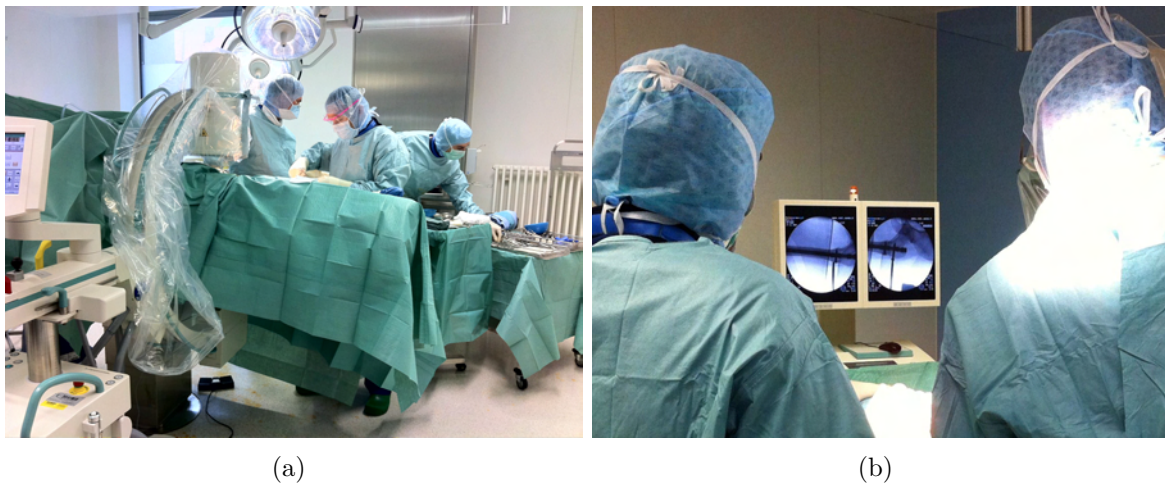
(a) A typical mobile C-arm fluoroscope used during orthopedic surgery; (b) Acquired projection X-ray images displayed on monitors. The images are taken from a surgery performed by Dr.med. Peter-Helmut Thaller at Klinikum Innenstadt, LMU, München
